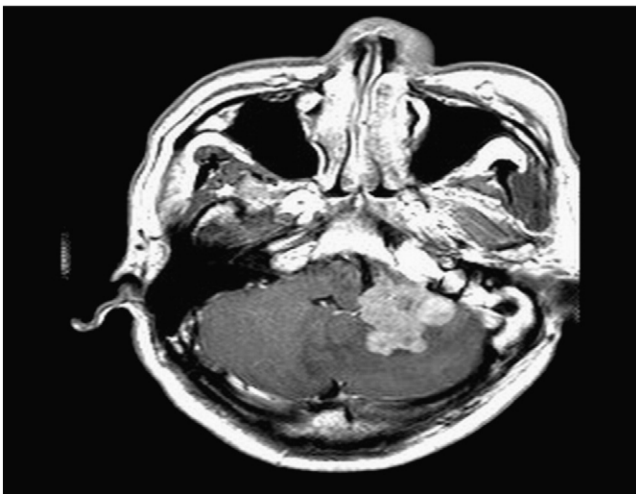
Radiographic findings. Axial T1-weighted image with contrast enhancement reveals a heterogeneously enhanced lesion at left anterior cerebellopontine angle with lobulation formation.
